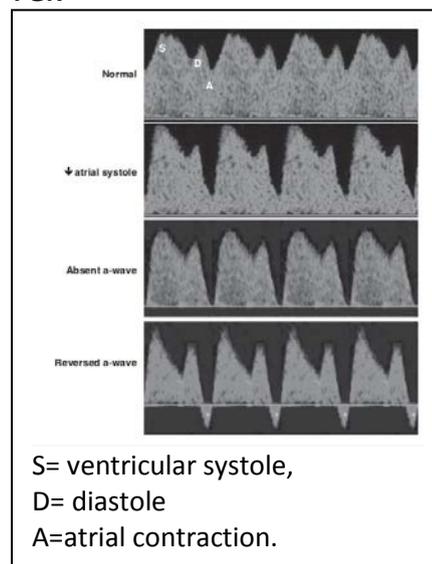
Progressive changes in ductus venosus Doppler waveforms as hypoxia increases in early onset FGR⁴⁰
